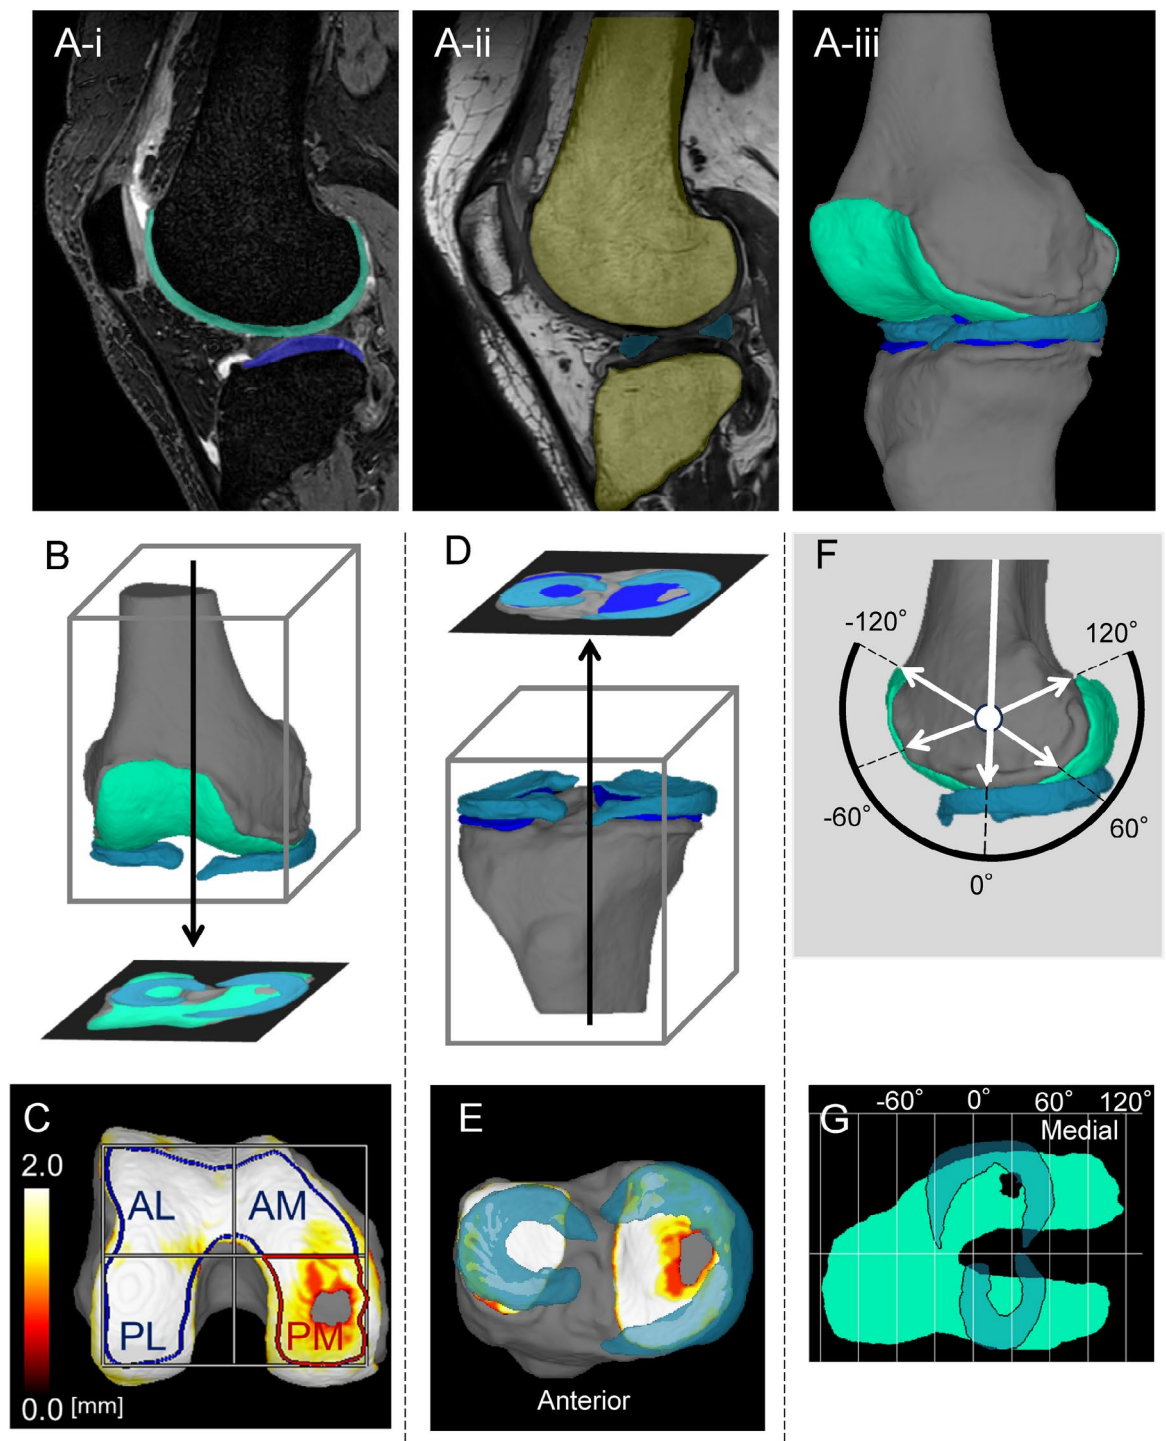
3D MRI analysis of the right knee with medial OA. (A) Sagittal and 3D images. (i) Sagittal SPGR image. Fully automatically extracted femoral cartilage is shown in green and tibial cartilage in dark blue. (ii) Sagittal PDW image. Fully automatically extracted bone is shown in yellow and meniscus in blue. (iii) 3D image. Bone is shown in gray, cartilage in green and dark blue, and menisci in blue. (B) Scheme showing the vertically projected cartilage area from 3D femoral cartilage and menisci. (C) Cartilage thickness mapping and 4 regions of the femoral cartilage. PM, posteromedial femoral; AM, anteromedial; PL, posterolateral; and AL anterolateral. (D) Scheme showing the vertically projected cartilage area from 3D tibial cartilage and menisci. (E) Cartilage thickness mapping of the tibial cartilage and menisci. (F) Scheme showing the vertically projected cartilage area from 3D femoral cartilage and menisci. The centers of the medial and lateral epicondyles are determined in the lateral view. A plane perpendicular to the line connecting these centers is established. The cartilage and meniscus are then radially expanded. A line parallel to the femoral long axis passing through the center is set as 0 degrees. (G) Radially projected cartilage area from 3D femoral cartilage and menisci.
